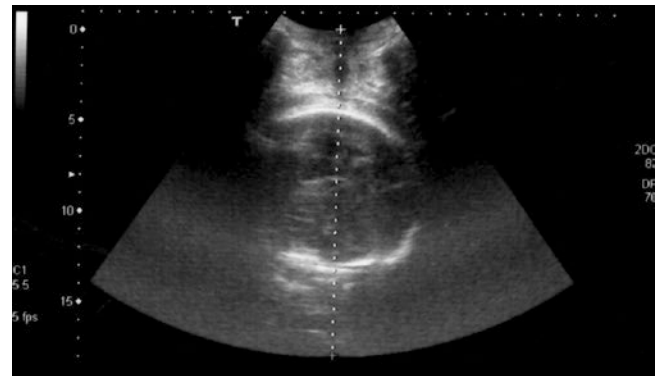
Translabial 2D ultrasonographic section in a dystocic second stage labor. The fetal head has a malrotation and a malposition in the pelvis. The *midline* angle is of 90° (the fetal *midline* crosses at 90° the anterior-posterior diameter, perpendicularly).
